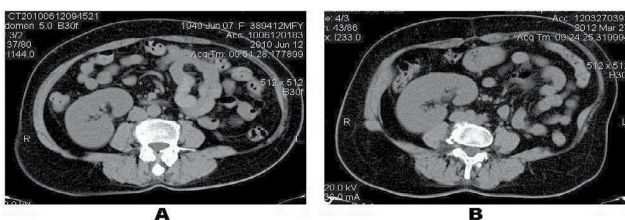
(A) Preoperative CT scan without contrast shows the layers of the musculature on the left side are much thinner than those on the right side. (B) the abdominal wall bulging appears during a Valsalva manoeuvre.
